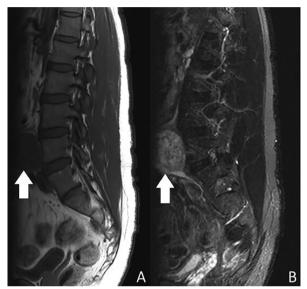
Sagittal lumbar MRI without contrast. A well-circumscribed lesion with signal isointense to the muscle in T1 weighed images (Panel A) and hyperintense signal in T2 weighed images (Panel B).
